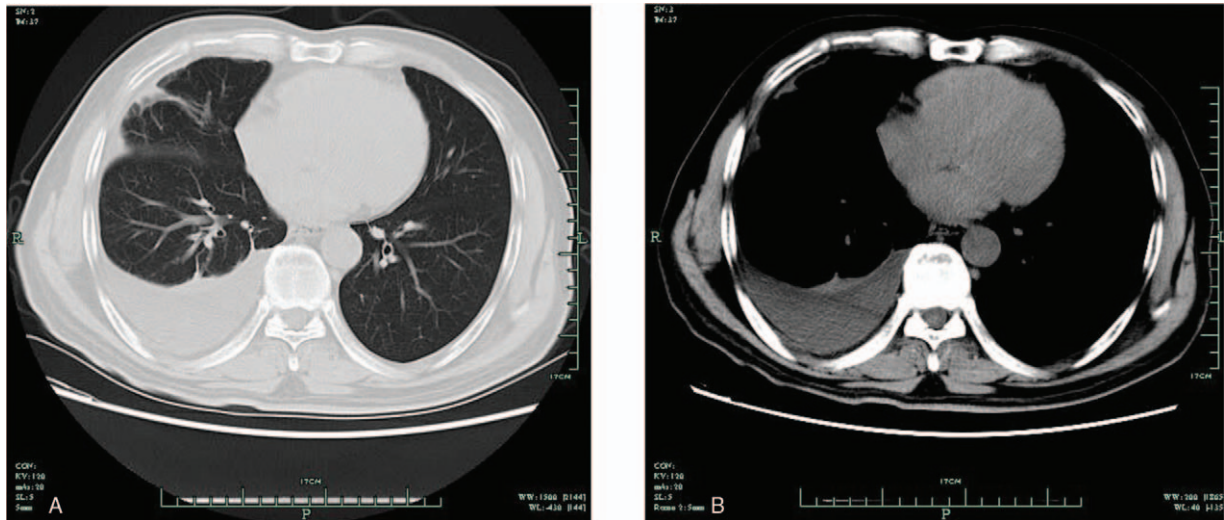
Computed tomography of the chest.
